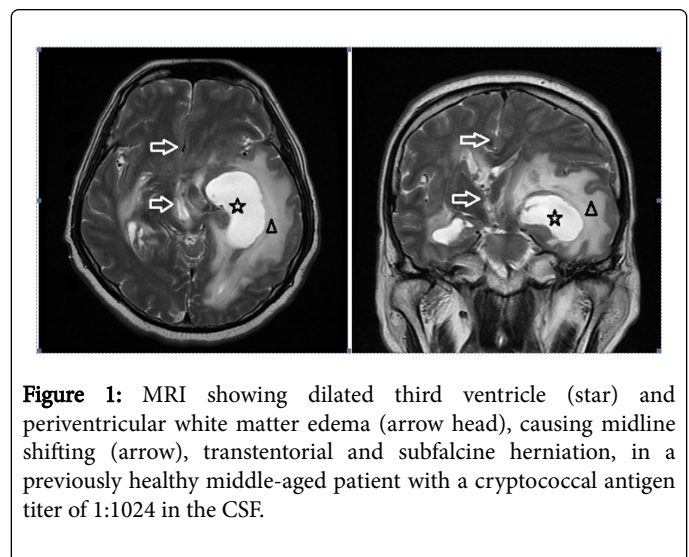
MRI showing dilated third ventricle (star) and periventricular white matter edema (arrow head), causing midline shifting (arrow), transtentorial and subfalcine herniation, in a previously healthy middle-aged patient with a cryptococcal antigen titer of 1:1024 in the CSF.
